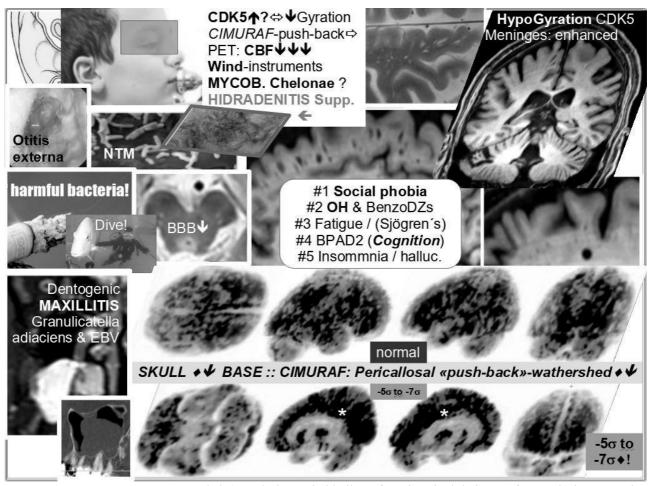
V#2mF1965: A MRI revealed a) Laplacian "wind-boilers" from impaired drainage of WM , b) hypo-gyration from likely genetic CDK5-hyperfunction and c) via PET-FDG unsuspected severe fine-speckled hypometabolism (-3 to (-5) -7 s): Bilaterally maximal (grey) at ventral thalamus, cerebellum, temporal poles and sides, central region, SPG, with spared precuneus. No correlated atrophy (MRI 2015/16). Stars (*) point to 90°-branches from pericallosal artery being occluded by intoxicating "push-back" by failing CIMURAF (Treviranus 2020), also touching basilary artery (Roloff 2016).
